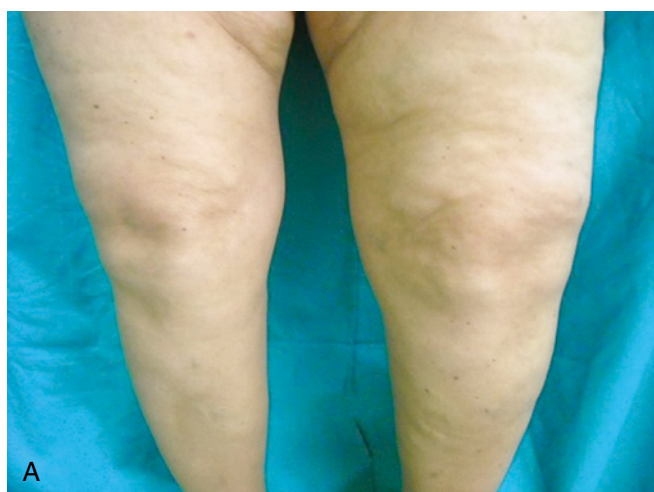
A, Ultrasound is used to evaluate the femoral condylar hyaline cartilage in a patient with knee osteoarthritis and varus deformity. B and C, The 12-MHz ultrasound images of the right and left knees demonstrate evident loss of sharpness and irregularities of the superficial and deep margins, asymmetric cartilage thinning, and changes in the anechoic echotexture.
